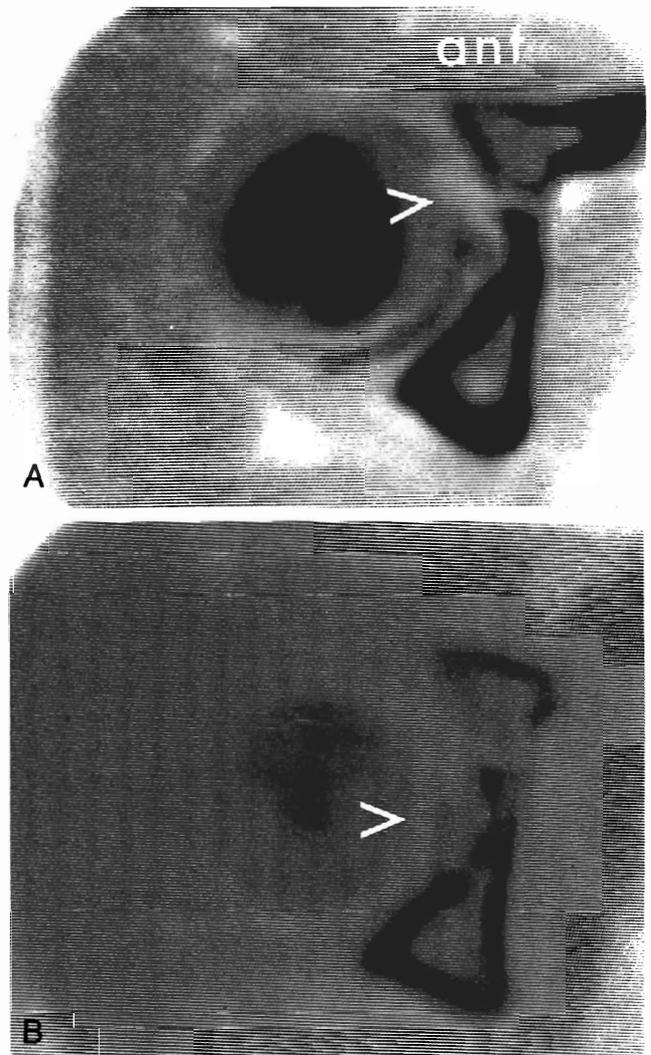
CT scan of a trapped intra-articular fragment following dislocation of the hip. (A) A filling defect in the arthrogram. (B) The fragment. At operation the ligamentum teres had been avulsed from the femoral head, and there was a second loose fragment, which came from the posterior acetabulum. (Courtesy of W. P. Bobechko.)
